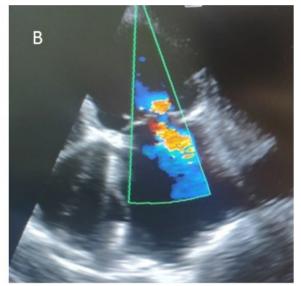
Visualization of Mitral Insufficiency using color Doppler imaging before the surgical intervention: A — before insertion of Intra-Aortic Balloon Counterpulsation; B — with the working Intra-Aortic Balloon Counterpulsation in the early postoperative period.
